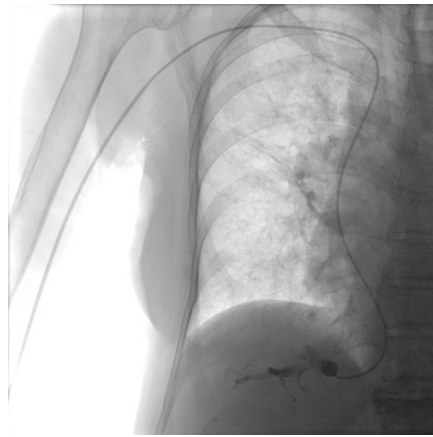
Chest and abdominal X-rays during hepatic venous pressure gradient measurement in procedure 28. The balloon catheter is inserted via the right cephalic vein. The catheter is inserted into the right hepatic vein. The balloon is inflated, and stasis of injected contrast medium is identified.
